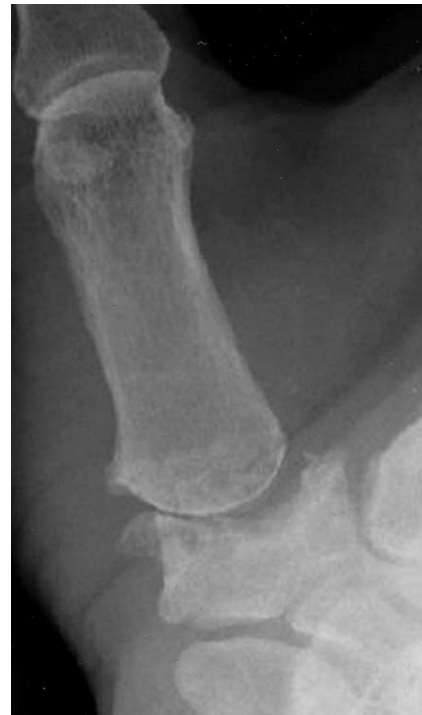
Postoperative radiograph showing the arthroplasty appearance with the newly created joint space.
